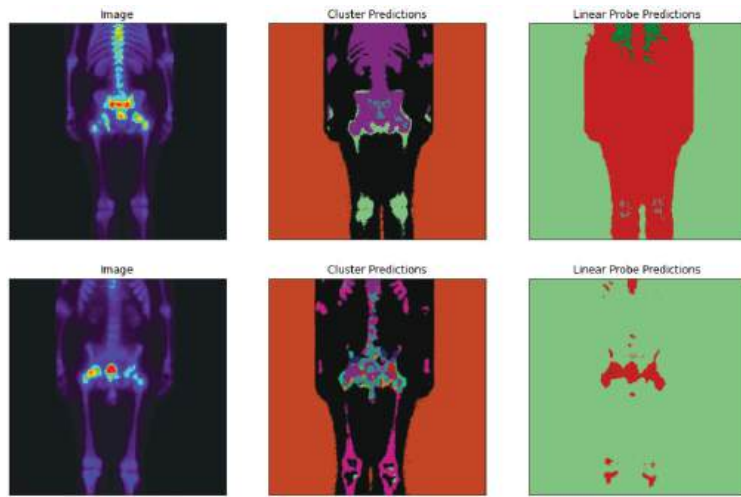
The initial scintigraphy image and incorrect STEGO outputs.
